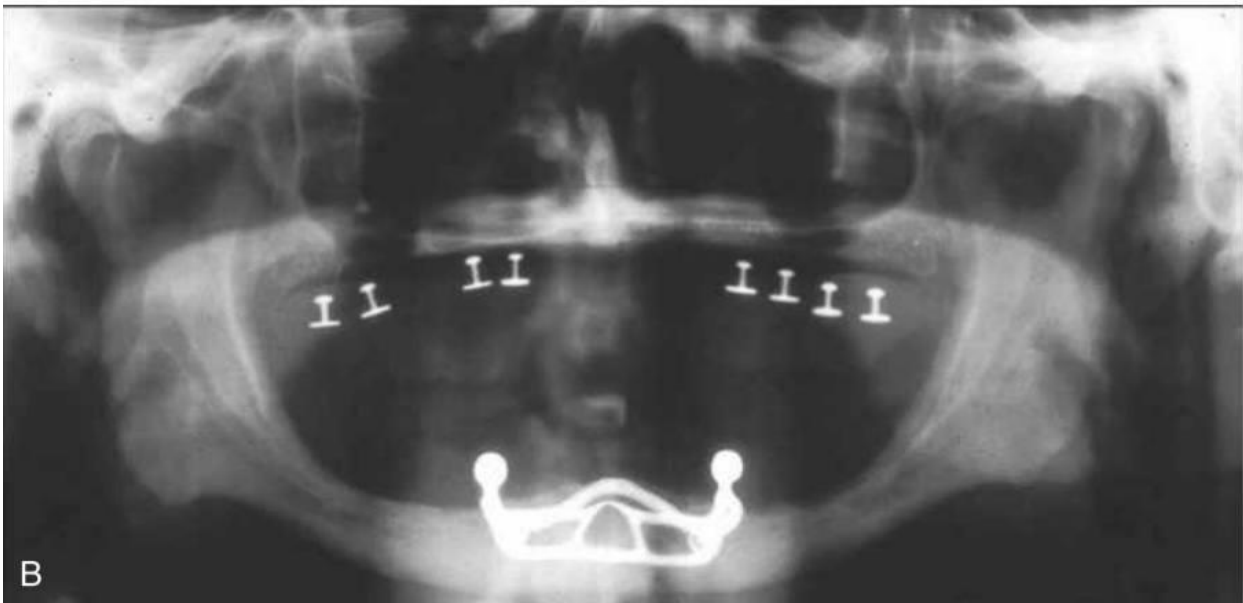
B, Radiograph of a sub-periosteal implant in the anterior mandible.
